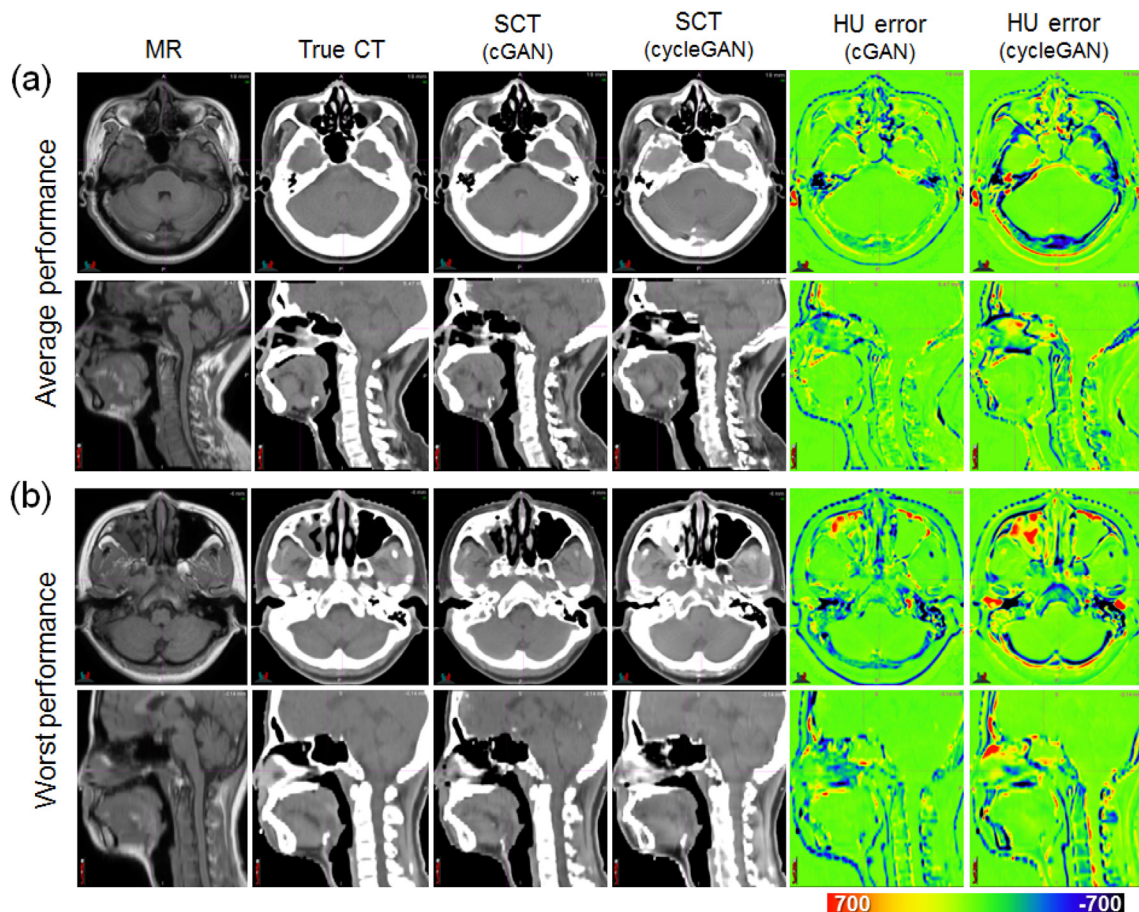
(a) Case with average HU accuracy in the generated SCT images (cGAN MAE = 68.44 HU; cycleGAN MAE = 94.01 HU). Case with the worst performance (cGAN MAE = 89.41 HU; cycleGAN MAE = 108.95 HU). (b) The SCT images were from the models trained with all samples. HU error = SCT – true CT. Abbreviations: cGAN = conditional generative adversarial network; cycleGAN = cycle-consistent generative adversarial network; MAE = mean absolute error; SCT = synthetic CT.
